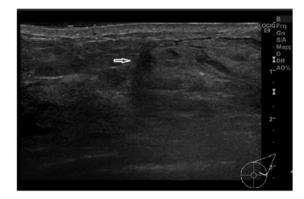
Ultrasound imaging showing diffuse edema and hypoechoic area with acoustic shadowing in the outer quadrants of the left breast.
